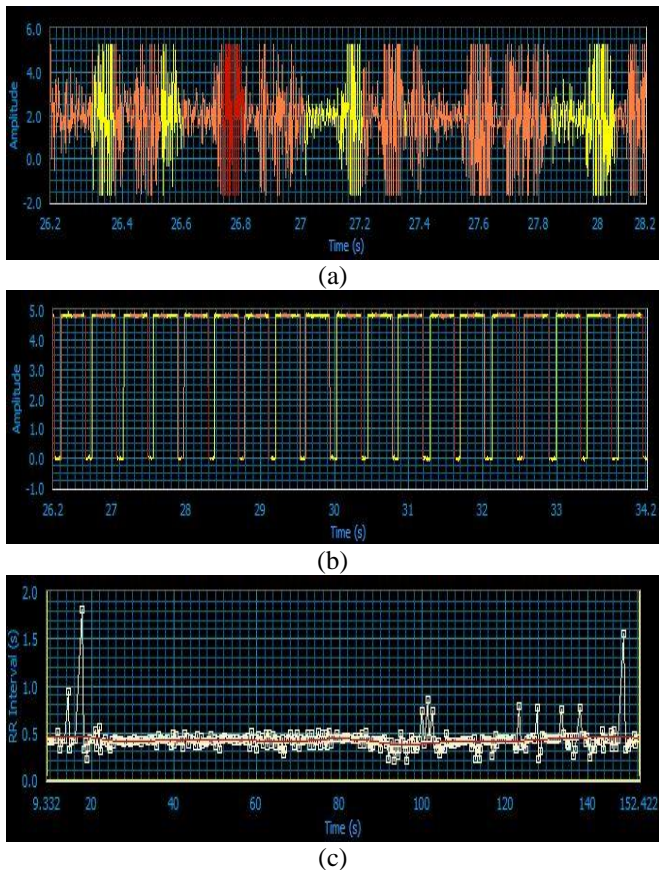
Result of Doppler ultrasound monitoring; (a) Recorded Doppler ultrasound signal (b) Converted Doppler
